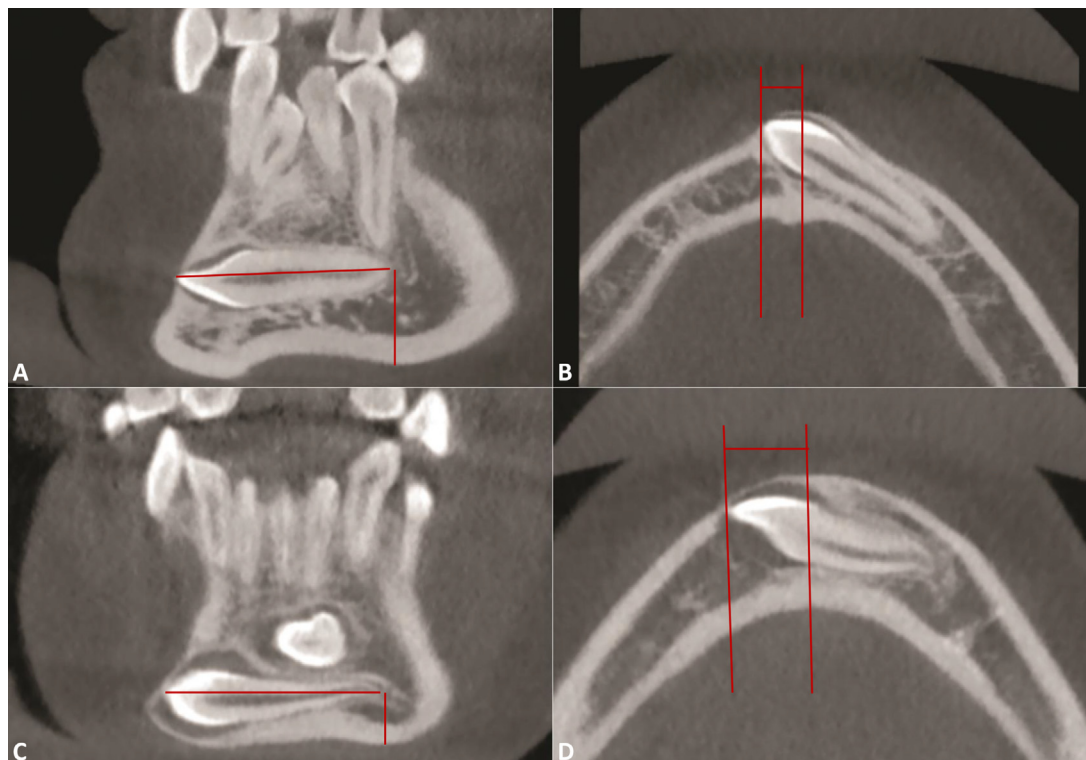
A and C, The lengths of the teeth in the successful and unsuccessful cases correspondingly, as well as the distances from the apex of the affected teeth to the mandibular border on the pretreatment CBCT images; B and D, The distance beyond the mandibular midline in the successful and unsuccessful cases correspondingly, on the pretreatment CBCT images.
